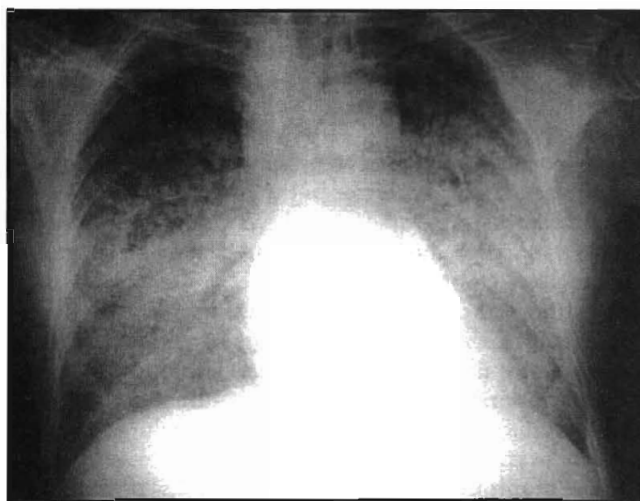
Chest radiograph showing cardiomegaly and pulmonary edema in an acute myocardial infarction patient with cardiogenic shock and multivessel coronary artery disease.
